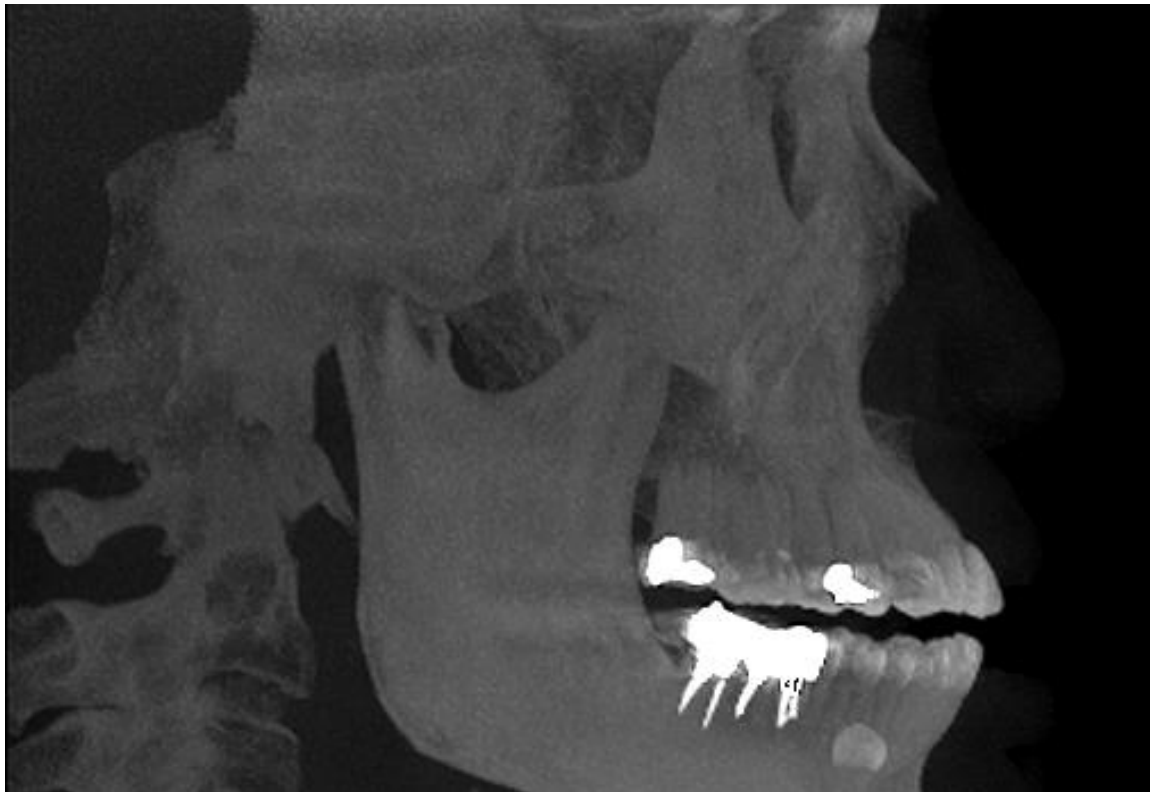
Lateral cephalogram rendered from CBCT image
